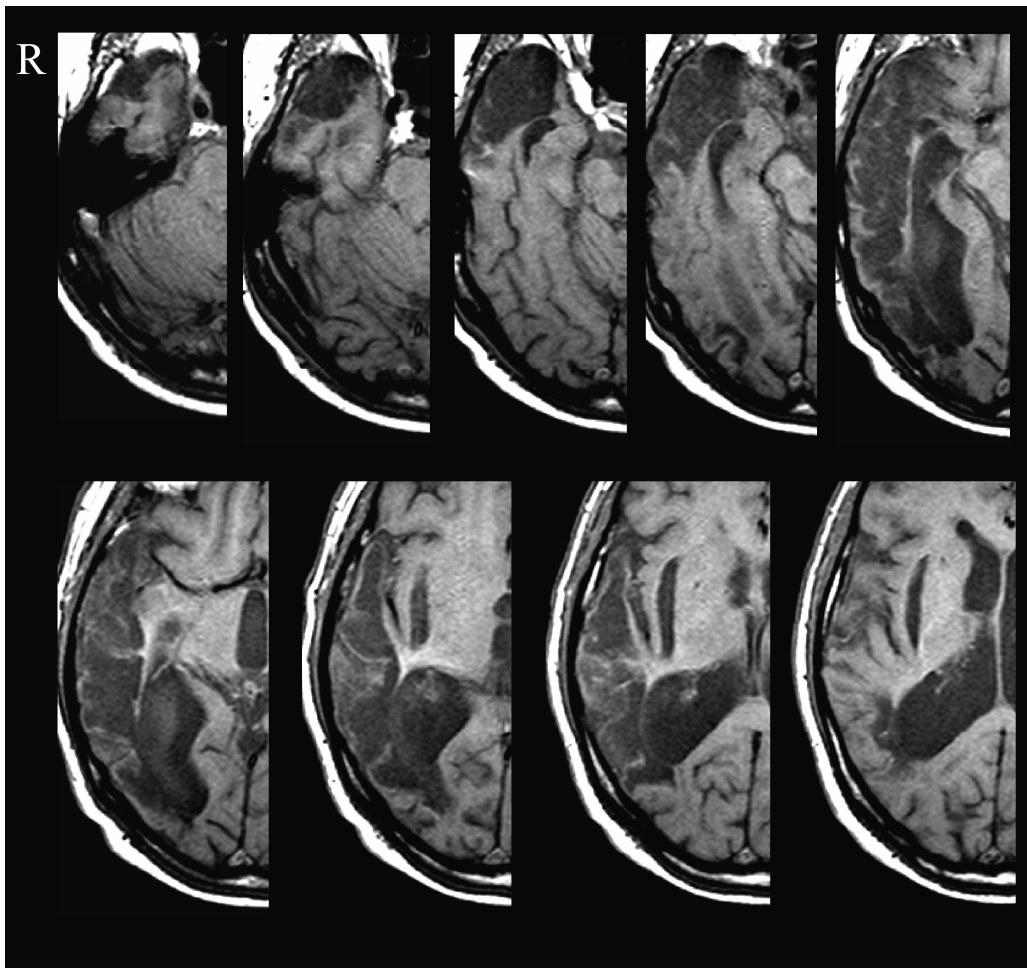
T1 MRI of FZ (at age 58) showing his right temporal brain lesion. Left side of the image = Right side of the brain.
